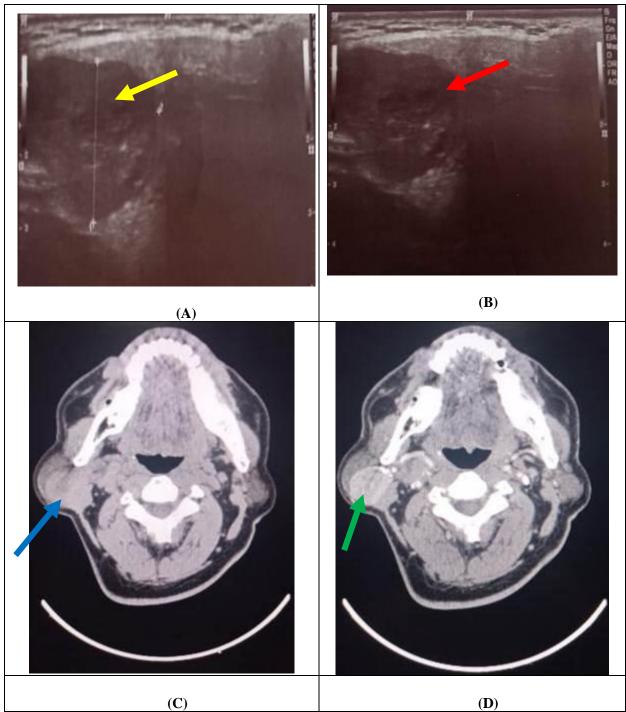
60 years male patient complained of painless swelling in right parotid region 1 year ago, neck ultrasound done showing well-defined hypoechoic soft tissue mass lesion seen within right parotid (A yellow arrow) with faint internal vascularity on color Doppler study (B red arrow), CT neck with IV contrast showing diffuse swelling of the right parotid gland with solid lesion showing homogenous intensely contrast enhancement (C without contrast blue arrow), (D with contrast green arrow). Diagnosed as right parotid gland pleomorphic adenoma and final diagnosis was right parotid gland pleomorphic adenoma (Mixed salivary gland tumor).
